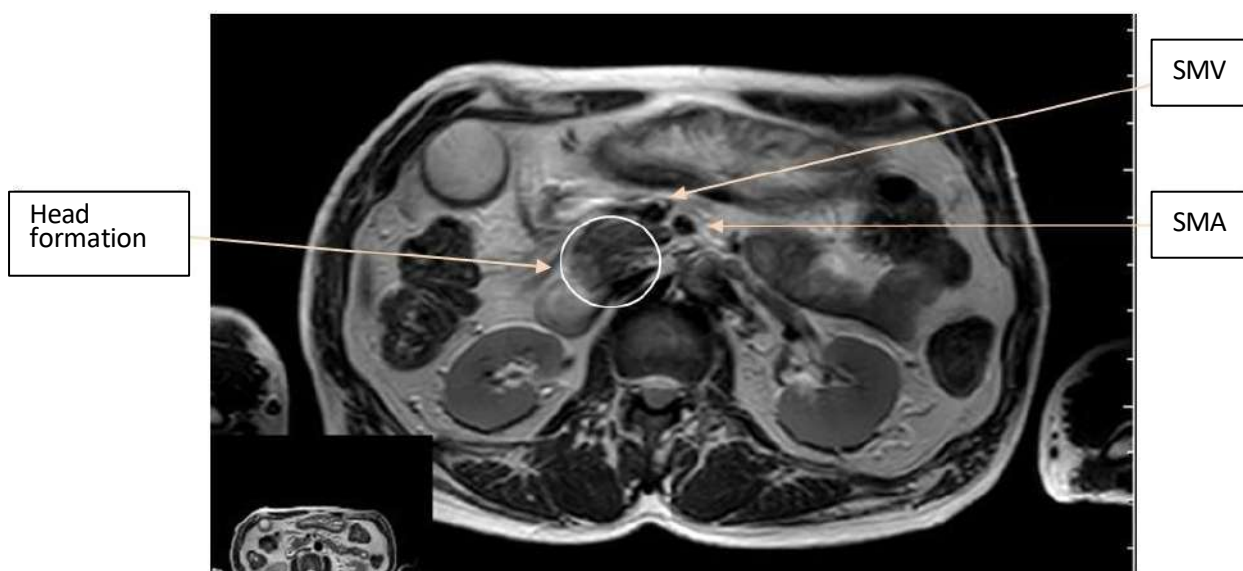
Magnetic resonance imaging, T2-VI. A volumetric mass of the pancreatic head is visualized, encircling the SMV $>180^\circ$
